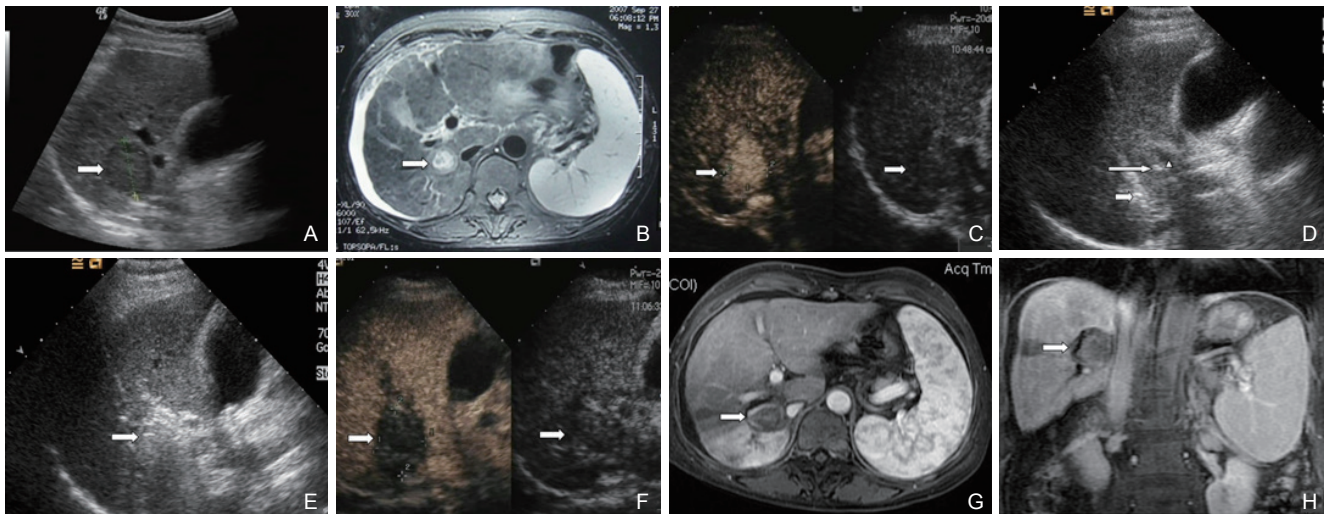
A 55-year-old woman with hepatitis B virus-related cirrhosis and HCC in the right lobe of the liver treated with RF ablation combined with PEI, and the tumor is adjacent to the hepatic hilum. (A) Gray-scale ultrasound shows the tumor (arrow) was hypoechoic and adjacent to the hepatic hilum; (B) CEUS shows the tumor hyper-enhanced (arrow) in the arterial phase; (C) MRI shows the tumor (arrow) located adjacent to the hepatic hilum; (D) The RF ablation electrode (short arrowhead) is placed into the tumor and the PEI needle (long arrowhead) is placed into the margin of the tumor proximal to the right hepatic duct (Δ); (E) During the therapy, the hyperechoic area of ablation (arrow) is monitored by real-time US; (F) One day after ablation, the ablated zone (arrowhead) is evaluated by CEUS and the tumor is completely destroyed; (G) Six months after ablation, MRI shows the tumor is completely destroyed (arrow); (H) Twelve months after therapy, MRI coronal plane scan shows the ablation zone (arrow).
